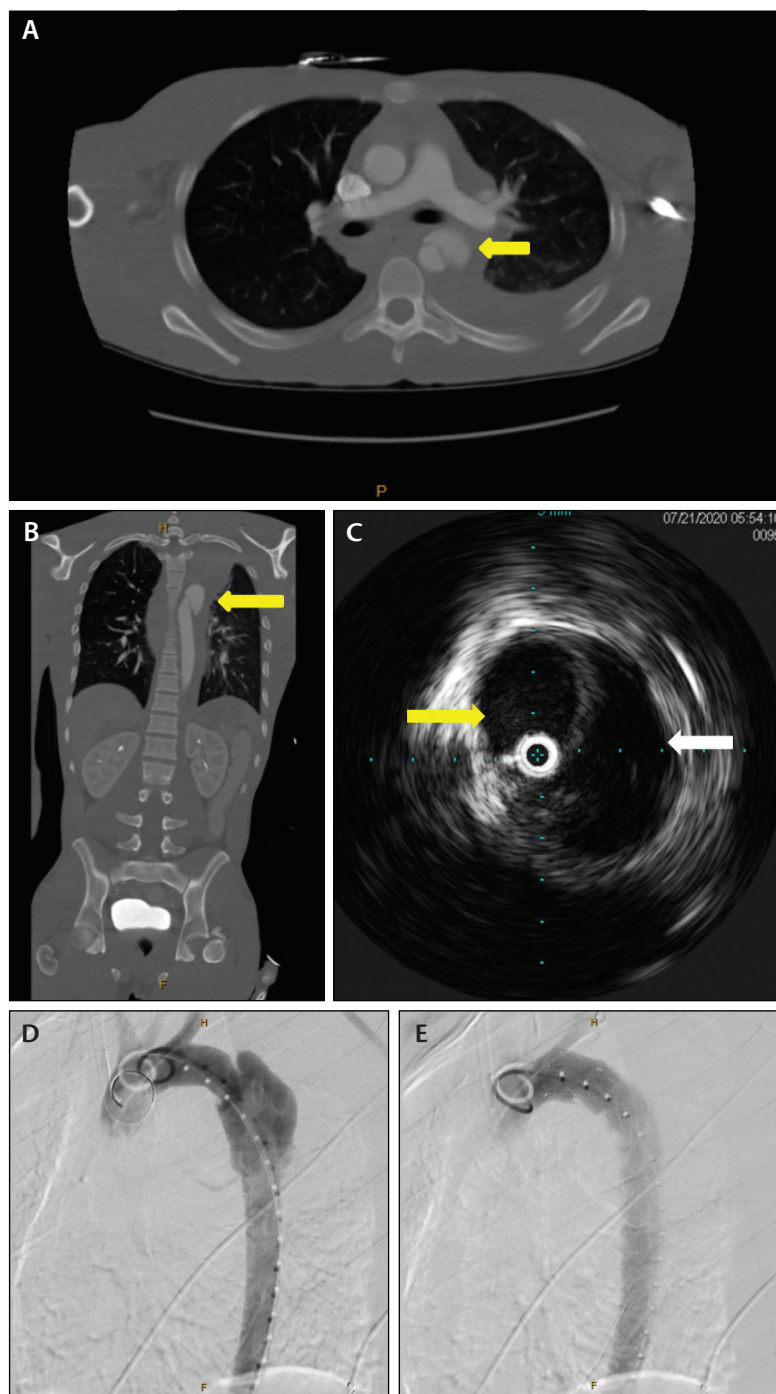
Grade 3 traumatic disruption of the proximal descending thoracic aorta secondary to motor vehicle accident in a 26-year-old man. Axial (A) and coronal CTA (B) revealed an intimal flap, pseudoaneurysm, and apical hematoma (yellow arrows). IVUS was used to optimize stent graft sizing with measurements during systole (C); the true aortic lumen (yellow arrow) and pseudoaneurysm (white arrow) are well distinguished on IVUS. Intraoperative angiogram before and after covered stent placement images (D, E). Exclusion was feasible in this case without subclavian artery coverage.
